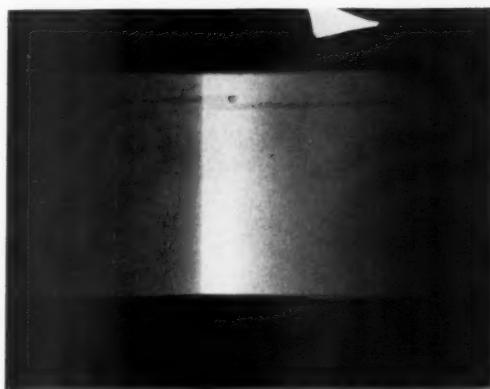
Radiograph of a square pendulum (period slightly less than 1 sec.). The exposure began while the pendulum was at the right end of its swing (during a period of relatively no movement), and continued during its swing toward the observer's left. Note the sharp margin of the square on the right and the indistinct margins on the left. In this latter region the silver emulsion had been affected by direct exposure prior to the swing of the pendulum to this position, leaving a much decreased amount to cast the shadow of the pendulum during this portion of its swing.
